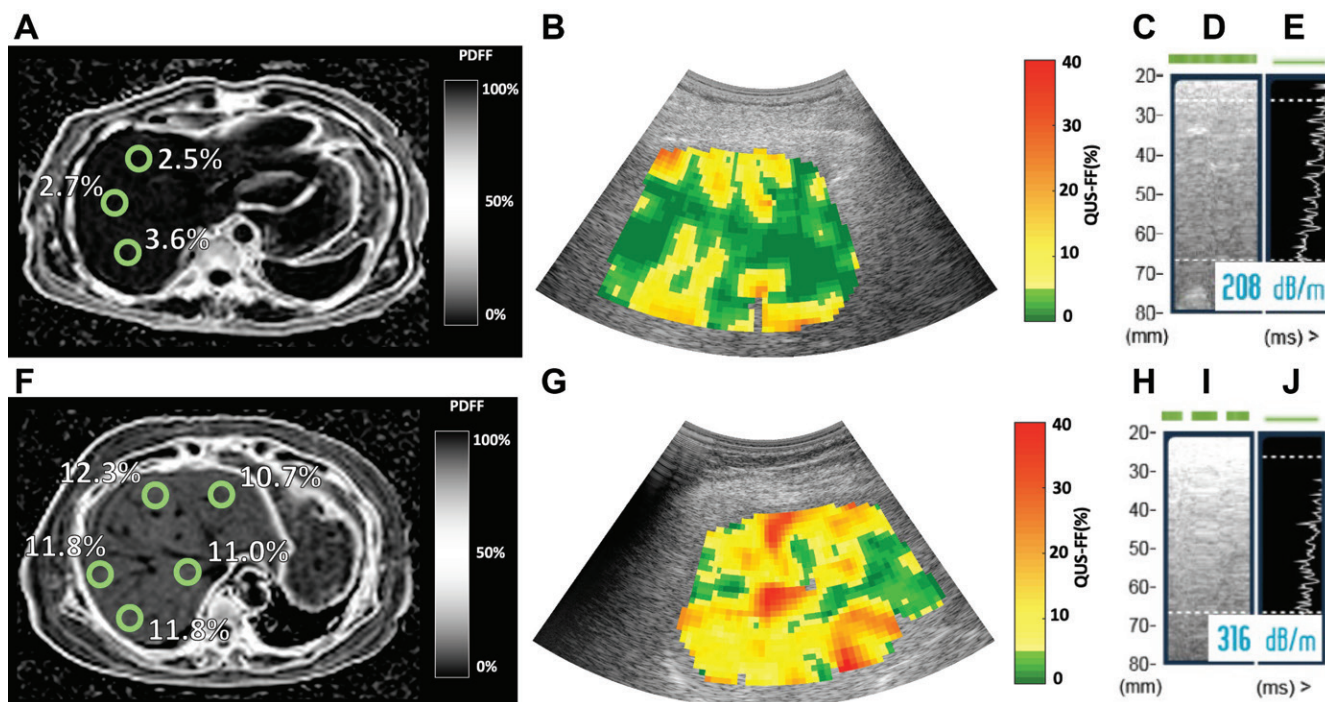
MRI-derived proton density fat fraction (PDFF), quantitative US (QUS), and controlled attenuation parameter (CAP) images in two representative participants. MRI-derived PDFF values were 2.6% in a 45-year-old man (top row) and 11.5% in a 67-year-old woman (bottom row). For CAP, valid image representation closest to the reported value has been selected as the representative image. (A, F) Representative MRI-derived PDFF images. Circular regions of interest (radius, 1 cm) have been placed on each of the nine Couinaud segments. For this analysis, MRI-derived PDFF values from liver segments five through eight were averaged and used as the reference standard for hepatic fat content. (B, G) Representative QUS fat fraction (FF) images. B-mode reconstructed US images including colorized FF maps (the parametric maps are not intended to show the distribution of fat in the liver; thus, average QUS FF value across the entire field of interest was recorded). Representative CAP images with (C, H) depth explored (in millimeters), (D, I) time-motion mode, and (E, J) amplitude mode.
